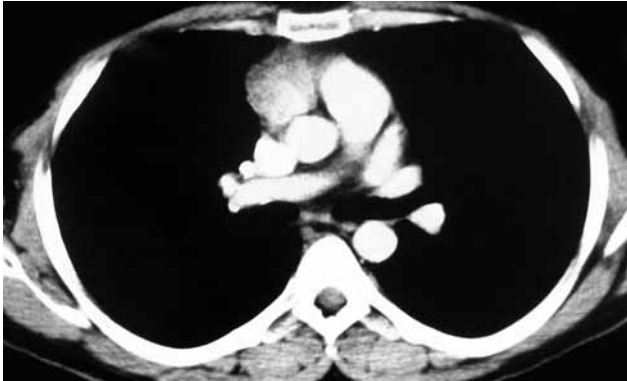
Computed tomography showing an anterior mediastinal mass.
